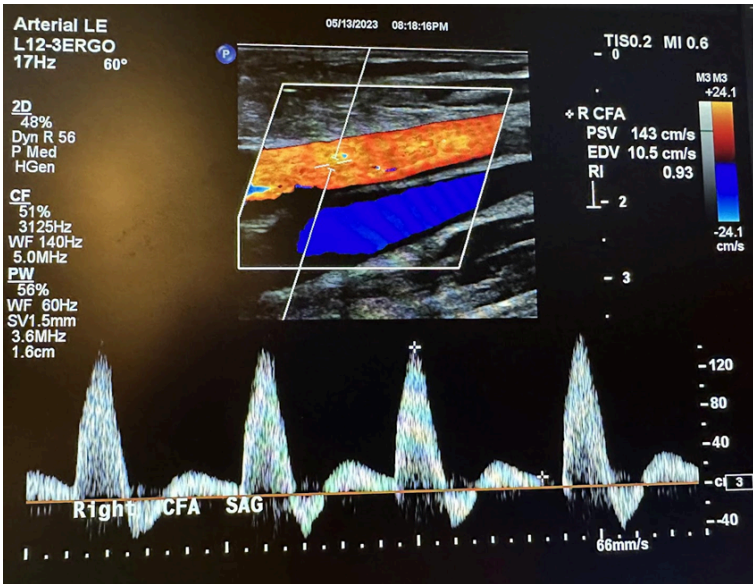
Sagittal image of the right common femoral artery with color Doppler and waveform analysis.
